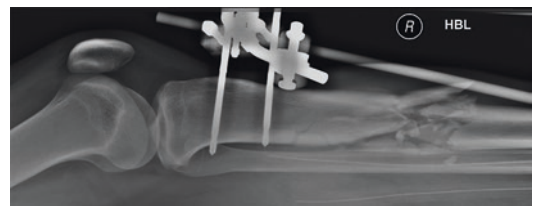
A lateral X-ray of a knee and proximal tibia with external fixator stabilising a multi-fragmentary diaphyseal fracture predictive of a high-energy transfer wound. Crown Copyright 2021
